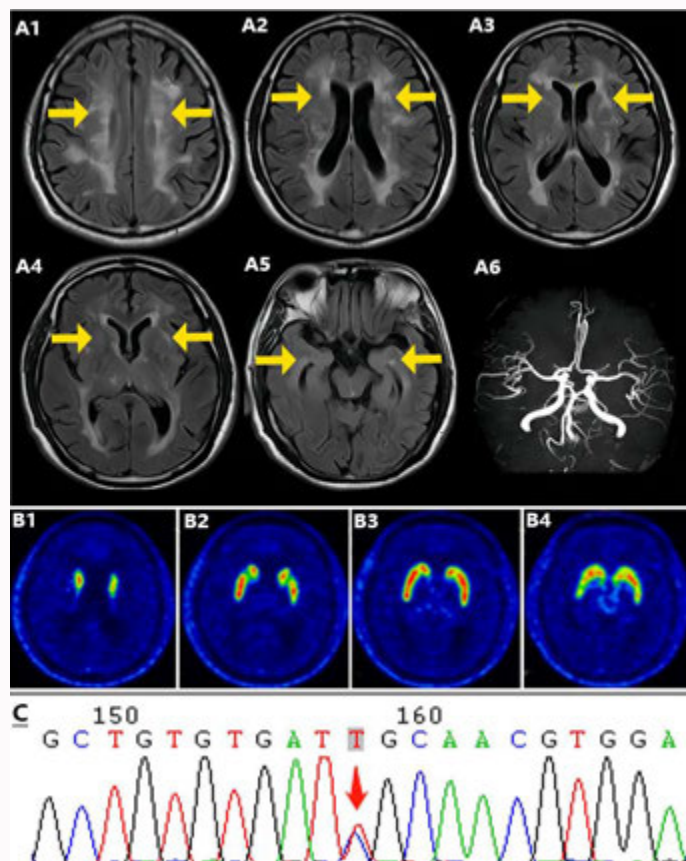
A1-A3) FLAIR and T2-weighted brain MRI, PET-MR, and Sanger sequencing. radiation crown and periventricular white matter hyperintensity. A4) white matter hyperintensity of the external capsule. A5) Bilateral temporal poles show normal signal. A6) No abnormalities in the intracranial vessels. B1-B4) PET-MR shows FDOPA uptake in the bilateral striatum was normal. C) Sanger sequencing confirmed the mutation.
